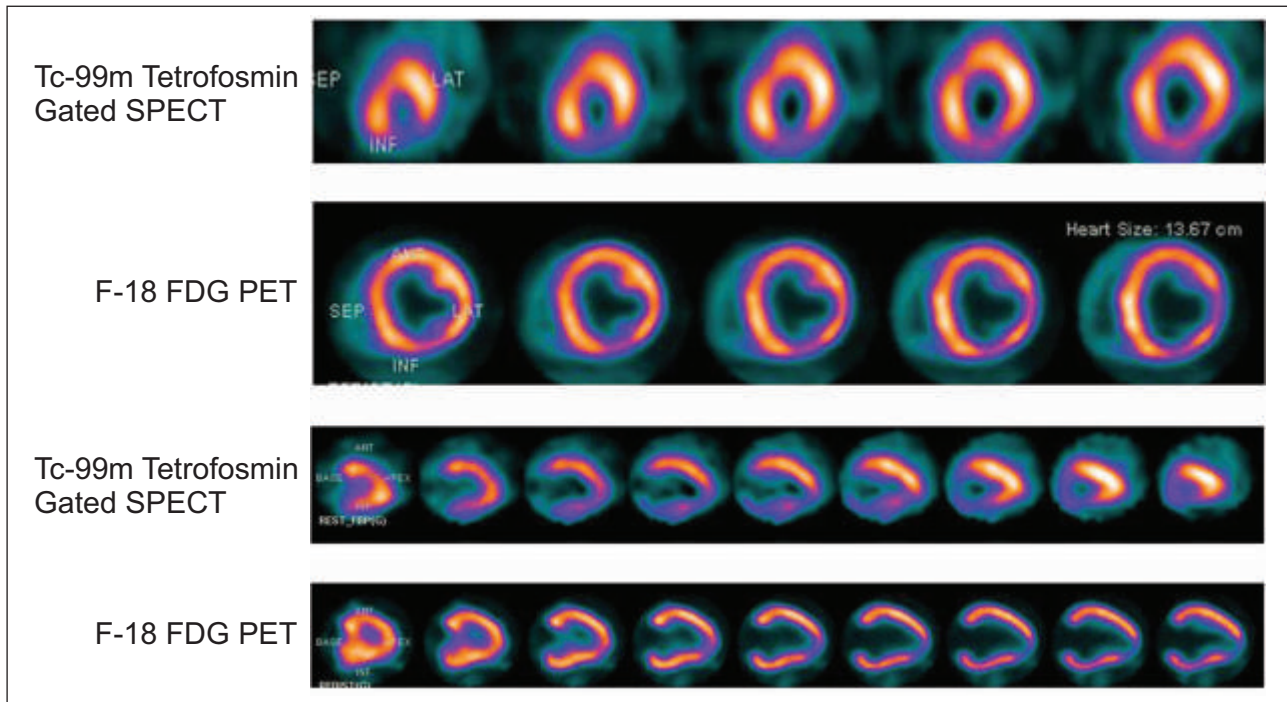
Tc-99m Tetrofosmin Myocardial Perfusion SPECT and F-18 FDG PET scans of a 46 year old male patient with old inferior wall myocardial infarction (MI) and recent anterior wall MI. He had angiographic evidence of triple vessel disease. Patient was referred for assessment of myocardial viability. There is evidence of mismatched myocardial perfusion and metabolism, which indicate presence of viable myocardium.
